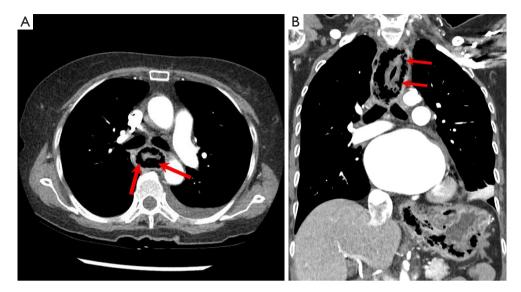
CT scans of a patient with emphysematous esophagitis with gastritis taken in the emergency room. Axial (A) and coronal (B) view of contrast enhanced chest CT show intramural gas of the esophagus (arrows). CT, computed tomography.
